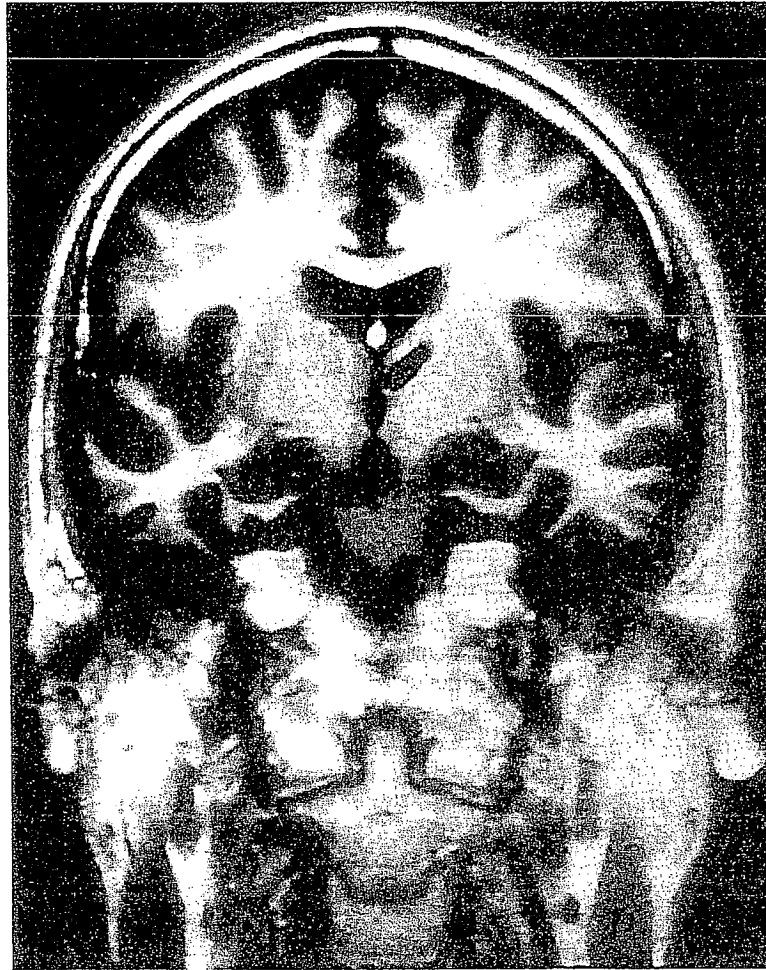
MRI scan of patient JR. Note the dark region in the centre. A small lesion in the region of the dorsomedial nucleus of the thalamus.
